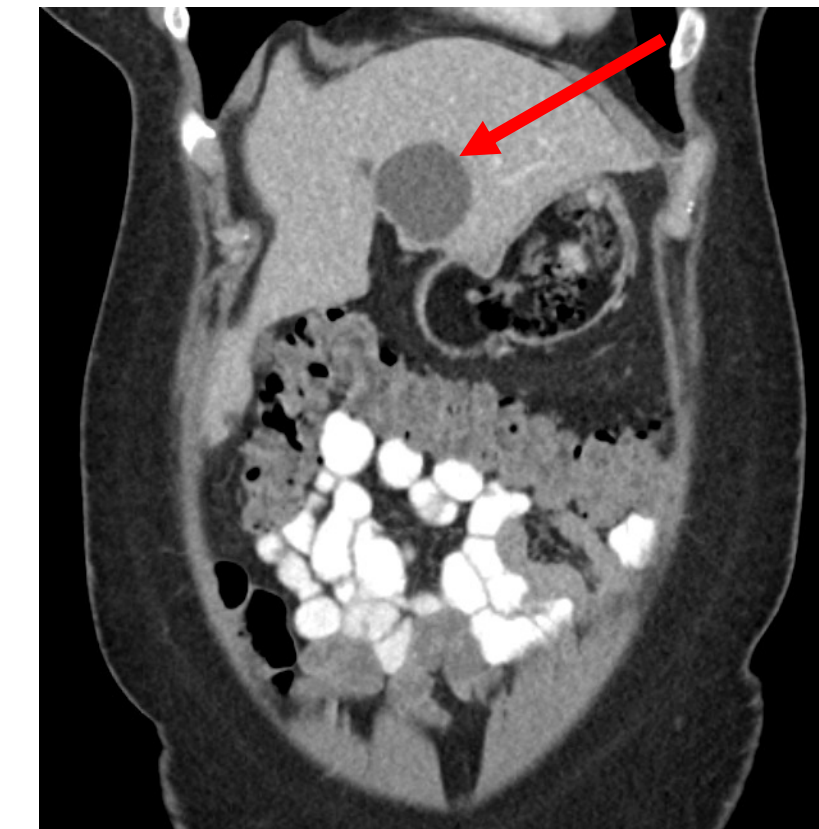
CT abdomen/pelvis showing hepatic cyst 1 month after initial ablation
